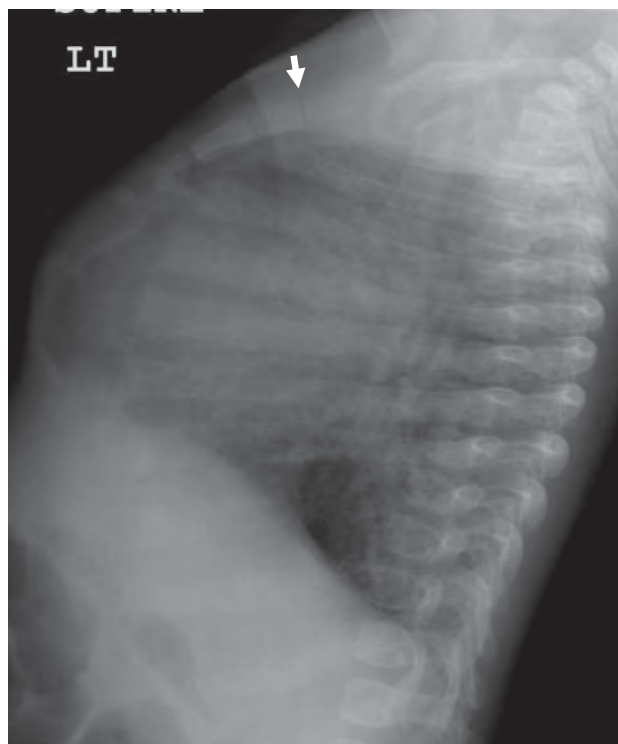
Lateral radiograph of the chest in a patient with known Down syndrome. Notice the hypersegmented manubrium (arrow) which is often seen in patients with Down syndrome on lateral view of the chest.
